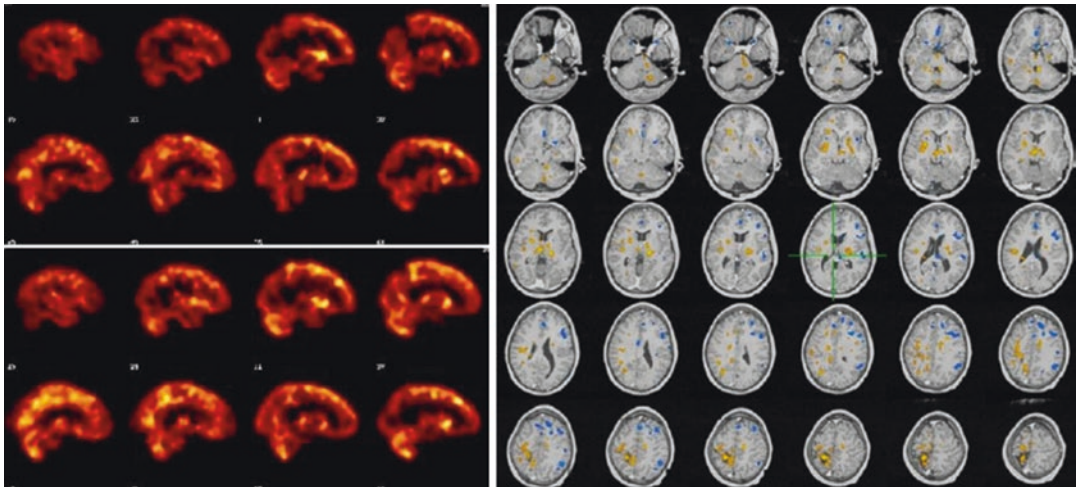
Same patient as shown in Fig. 11.42. (Left) images from an interictal ^{99m}Tc-ECD brain SPECT (top) as compared to an ictal ^{99m}Tc-ECD brain SPECT scan (bottom). One can see significant hyperemia anterior and inferior to the region of the arterial venous malformation on the ictal ^{99m}Tc-ECD brain SPECT scan as compared to the interictal ^{99m}Tc-ECD brain SPECT scan. (Right) SISCOM analysis where the ictal and interictal SPECT are compared and statistically significant differences
